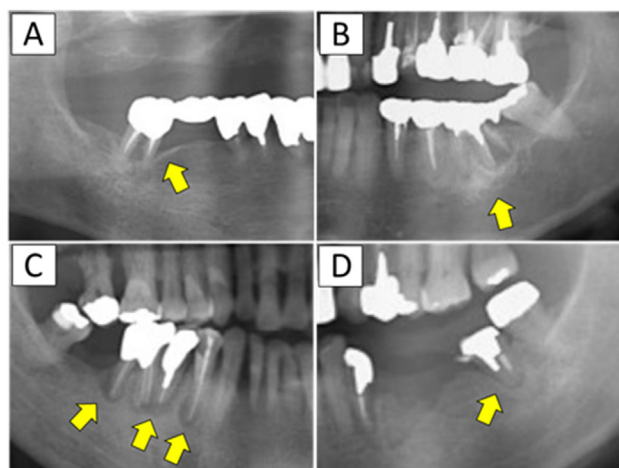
Panoramic radiographic findings. A: alveolar bone resorption, B: periapical osteosclerosis, C: apical lesion, D: enlargement of periodontal ligament space.
